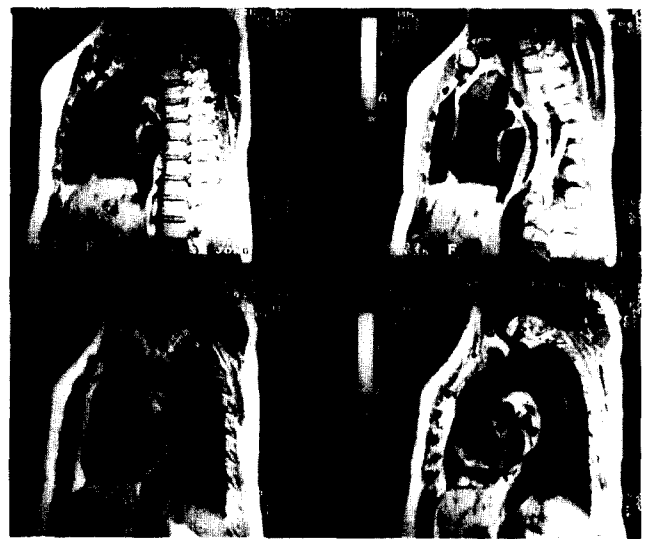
The MRI finding of an aortic dissection involving whole segment of aorta with intimal tear at the level of aortic isthmus.
